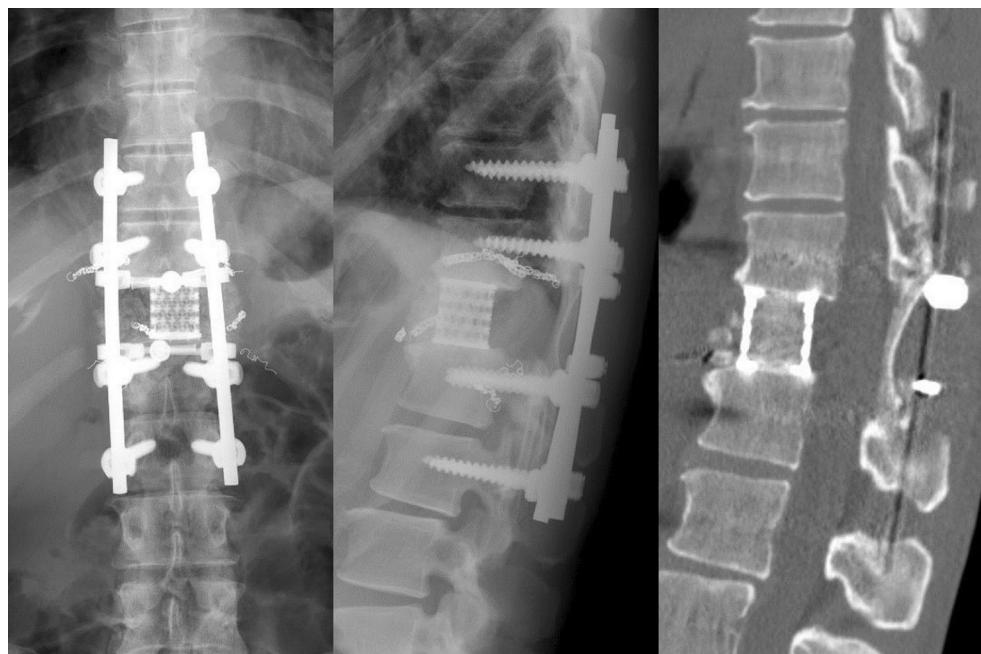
Postoperative radiological findings 1 year after total spondylectomy. Postoperative radiography and CT demonstrated that the reconstructed spine has been well-maintained with signs of radiographic bony union
